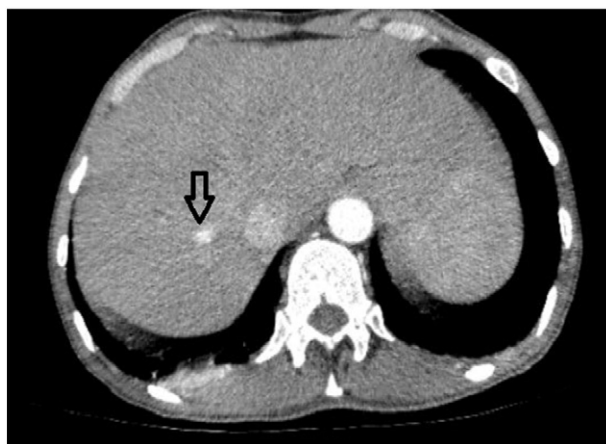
Hepatic CT angiography showing opacification of the right hepatic vein (arrow) and the retrocaval vena cava in the early arterial phase.
